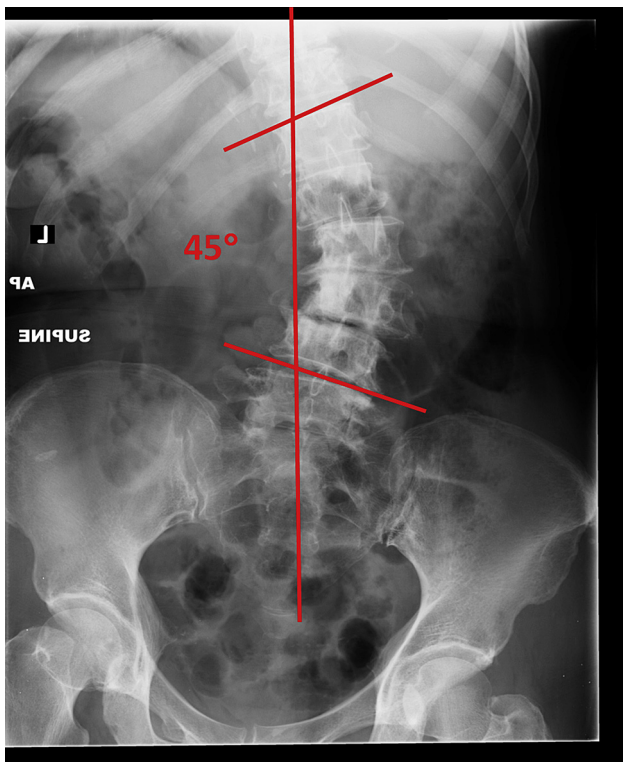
Preoperative supine AP X-ray of lumbar spine demonstrating 45° right-sided scoliosis from T12–L4.
